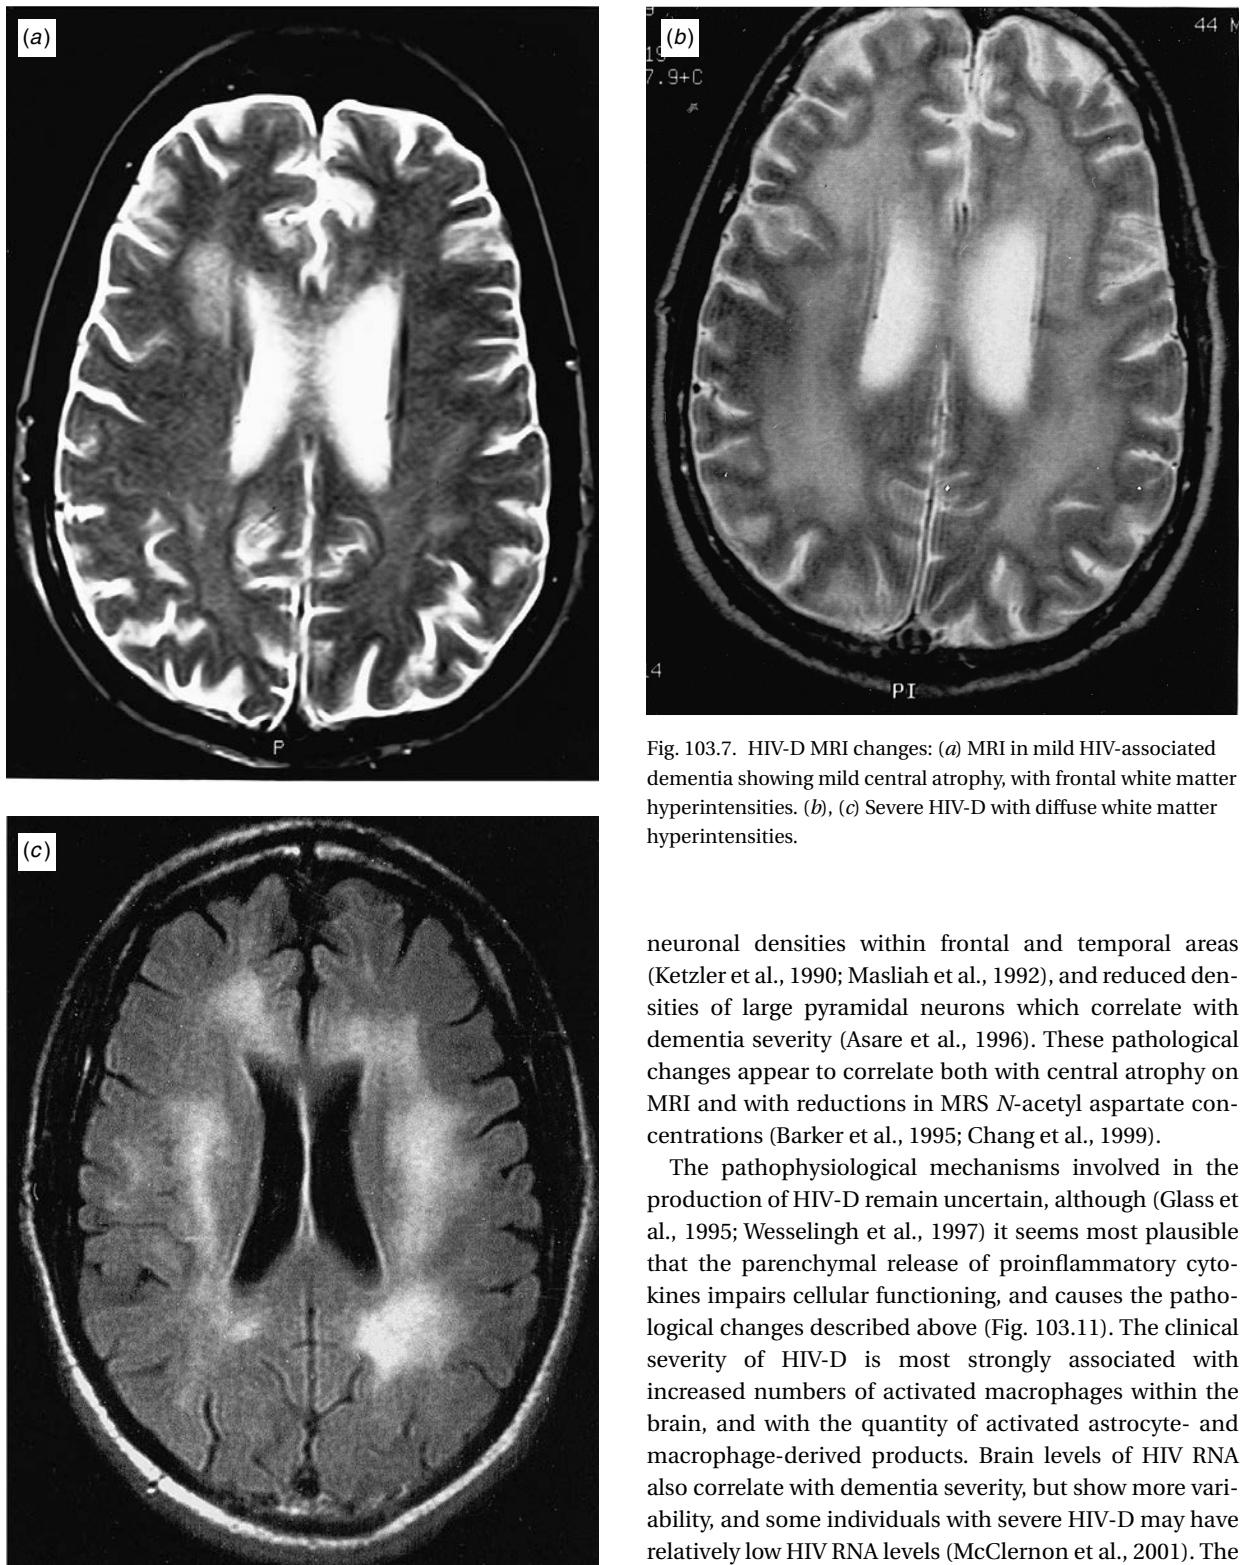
HIV-D MRI changes: (a) MRI in mild HIV-associated dementia showing mild central atrophy, with frontal white matter hyperintensities. (b), (c) Severe HIV-D with diffuse white matter hyperintensities.
